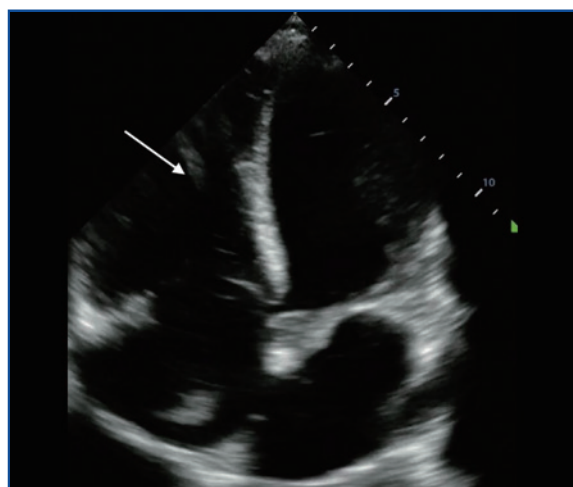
Enlarged right ventricle (arrow) in a patient with pulmonary embolism, in apical 4-chamber view. (Clinical photo from the author)
